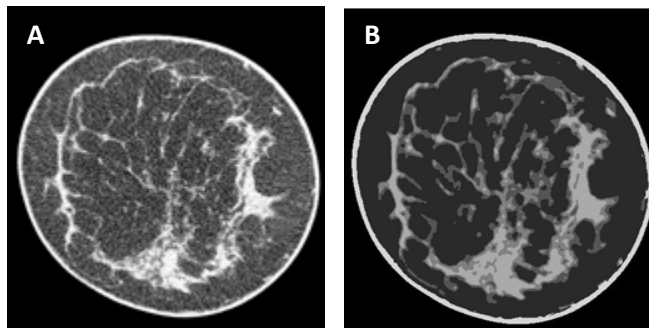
(A) original CT data. (B) Segmented CT data.
